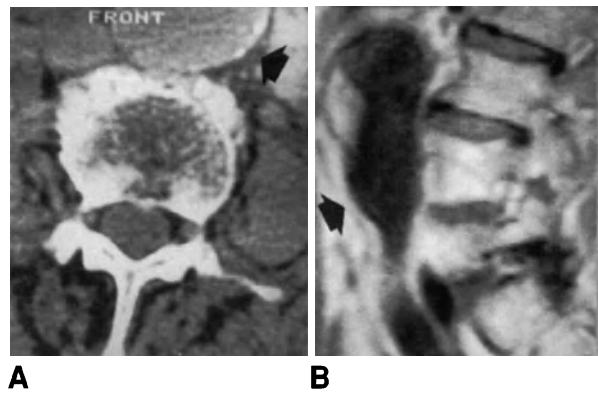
Aneurysm of the abdominal aorta responsible for a cruralgic syndrome. CT (A) performed for suspected lumbar disc herniation shows marked dilation of the abdominal aorta (arrow). The sagittal MR image (B) clearly demonstrates the aneurysm (arrow).
